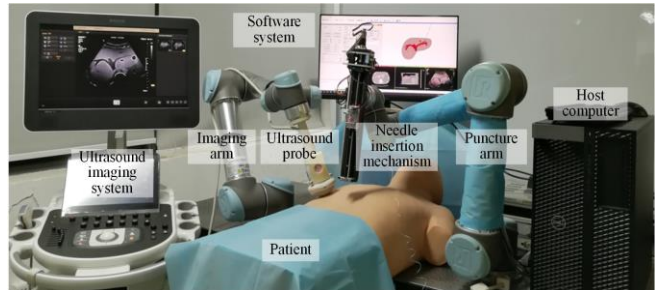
The developed dual-arm robotic needle insertion system with guidance of intraoperative 2D US and preoperative 3D CT fusion.
